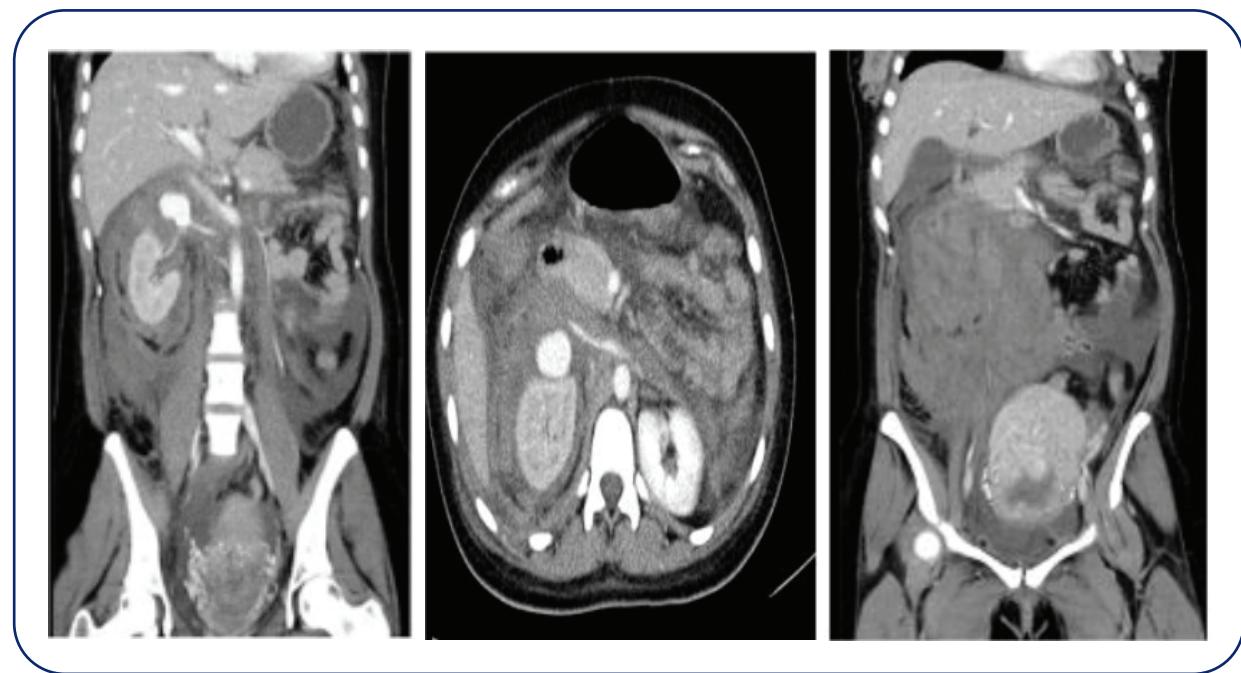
CT scan showed right RAA with active bleeding.
